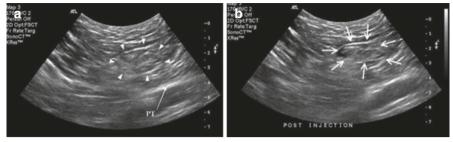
Ultrasound picture showing pre- and postinjection into the spermatic cord. (a) Spermatic cord before injection. (b) Spermatic cord after injection. This technique (as described by Peng et al.) blocks the genital branch of the genitofemoral nerve. The ultrasound is held perpendicular to the inguinal ligament, about one finger breath lateral to the pubic tubercle (Reproduced with permission from Philip Peng Educational Series)
